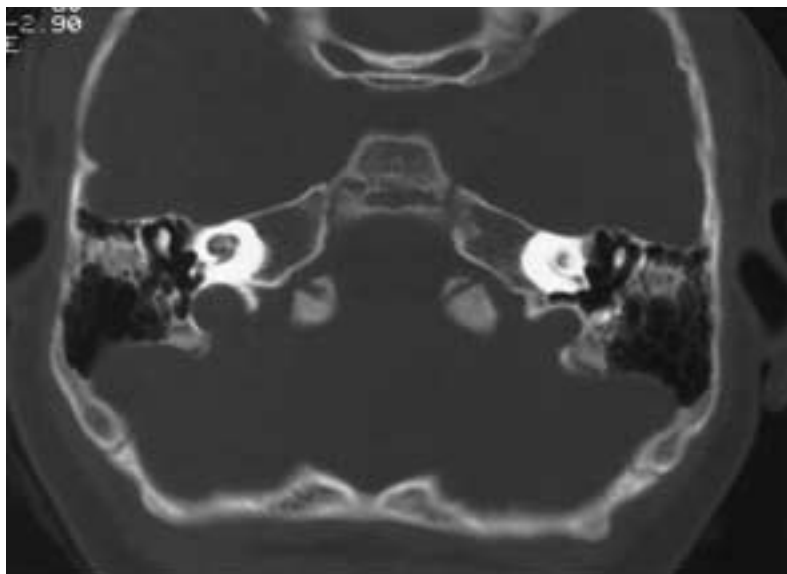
Labyrinthitis ossificans. Axial CT shows new bone formation partially obliterating left cochlea.
